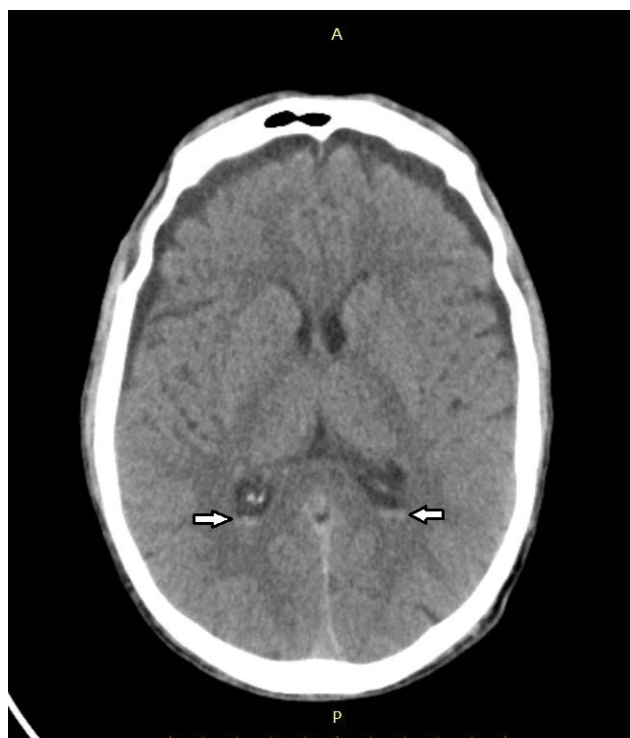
CT of a 47-year-old patient with severe TBI with intraventricular hemorrhage (white arrows) after a fall from height.
